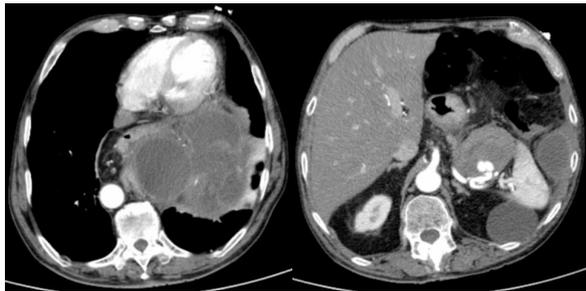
CTA performed at admission in the ER; CTA – Computed Tomography Angiography; ER – Emergency Department
